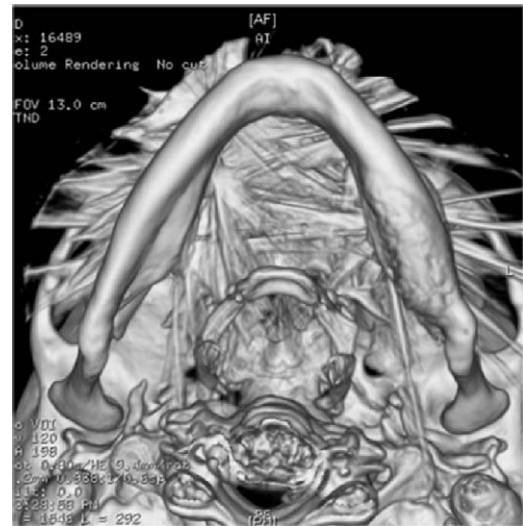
Bone window CT image in 3D reconstruction (axial plane) of the osteosclerotic lesion of the horizontal branch of the left mandible.
